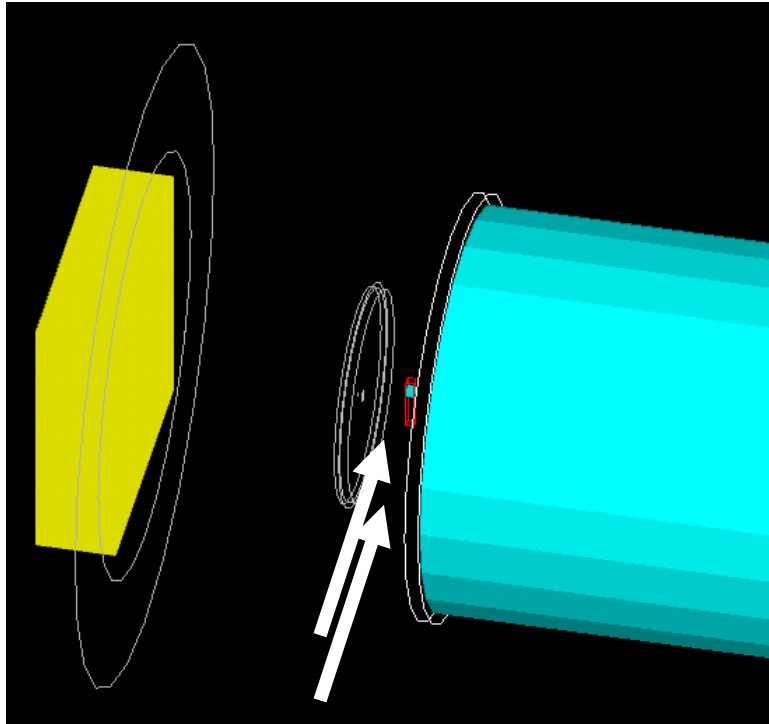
An Example for SPECT-like Trial
